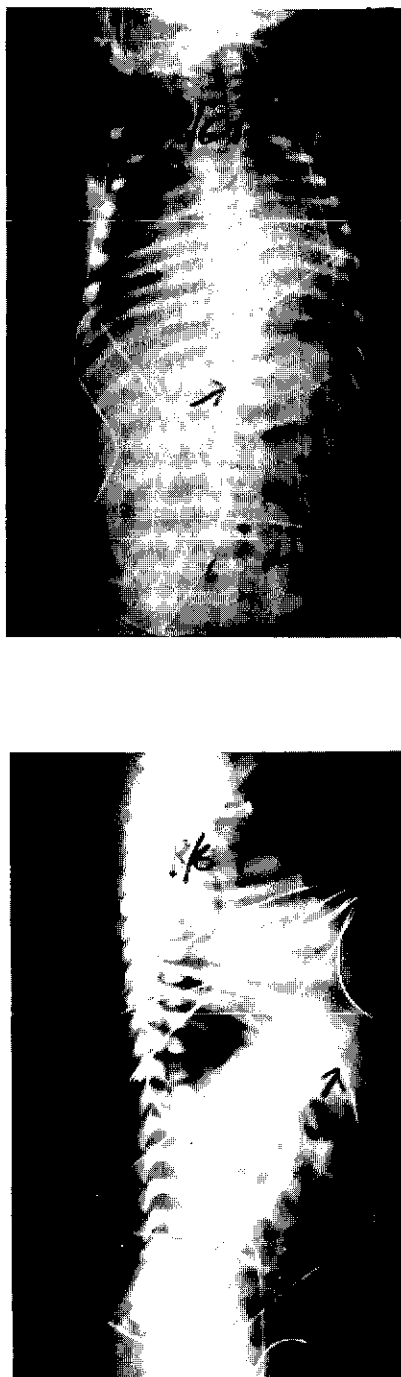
A (top), PA X-ray of infant with thermistors and an umbilical catheter in place; Note that maze of wires prevents identification of catheter position in this view. B (bottom), lateral with umbilical catheter in place and maze of thermistor wires attached to skin; this view clearly identifies that catheter has been inserted into an umbilical vein and is lying in portal system in liver.
